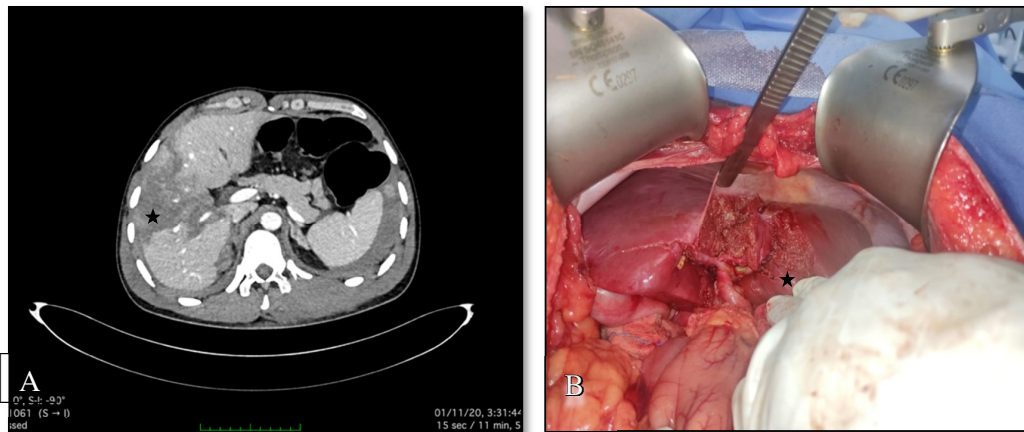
A- Axial cut Contrast-enhanced CT showing Grade 4 Liver laceration
